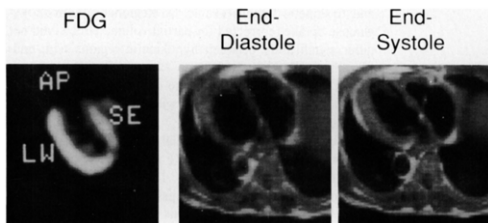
Matched positron emission tomographic study (left) and nuclear magnetic resonance imaging tomograms (middle and right) from a patient with a dilated left ventricle. Although the nuclear magnetic resonance images demonstrate reduced end-diastolic wall thickness with absent systolic wall thickening in the septum (SE), the positron emission tomogram shows 18 fluorodeoxyglucose (FDG) uptake (and thus preserved metabolic activity) in the same territory, suggesting the presence of asynergic but viable myocardium. AP = apex; LW = lateral wall.
